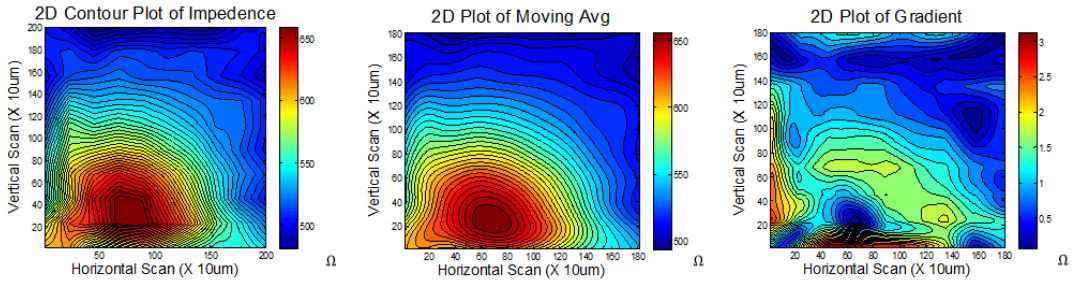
Figure b. Image of scanned impedance change for MRI derived brain model
